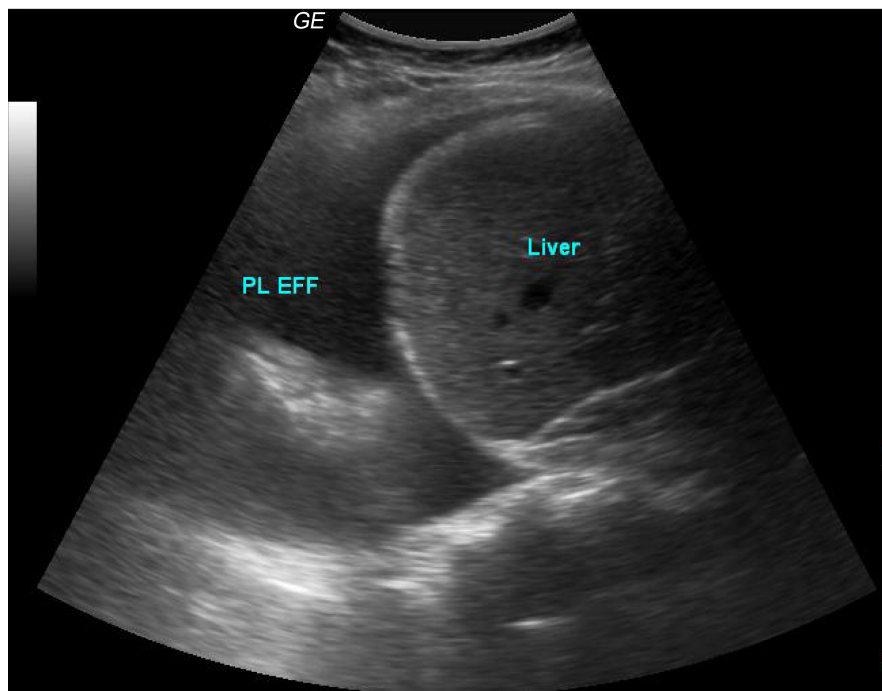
Sonographic appearance of echogenic effusion.
